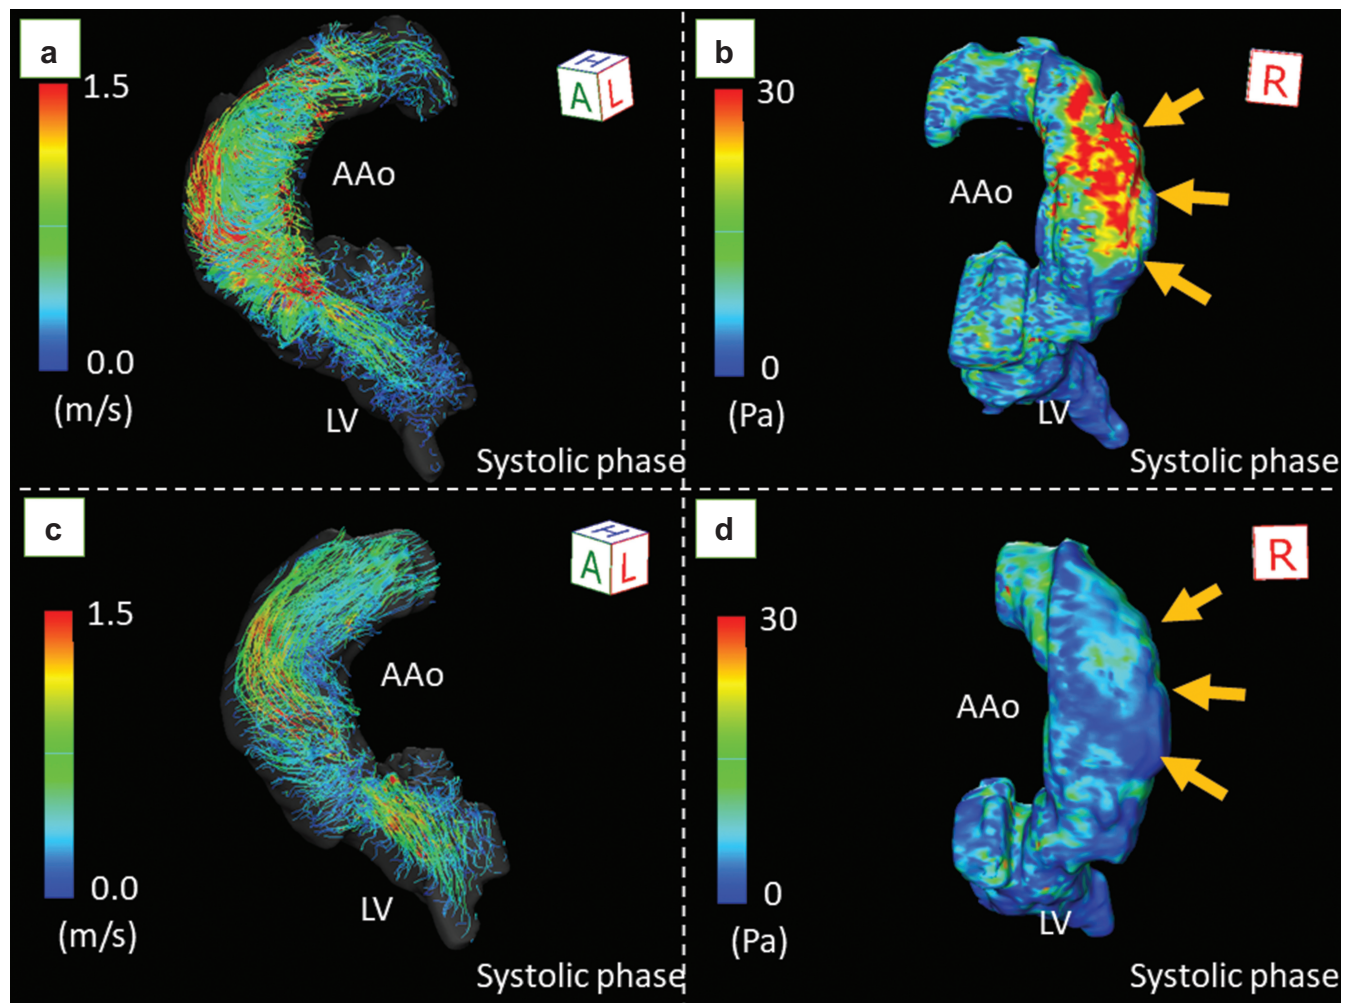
The change in wall shear stress before and after TAVI in a male patient with bicuspid aortic valve. Echocardiography revealed severe aortic stenosis with a transvalvular peak velocity of 5.3 m/s, mean gradient of 59 mmHg, and valve area of 0.83 cm². 4D flow MRI demonstrated markedly accelerated flow (a) with extremely high wall shear stress (39.7 Pa) at the right wall of the ascending aorta (b, arrows). After TAVI, the helical flow decreased (c), and the wall shear stress decreased to 8.4 Pa (d, arrows). AAo, ascending aorta; LV, left ventricle; Pa, pascal; TAVI, transcatheter aortic valve implantation.
